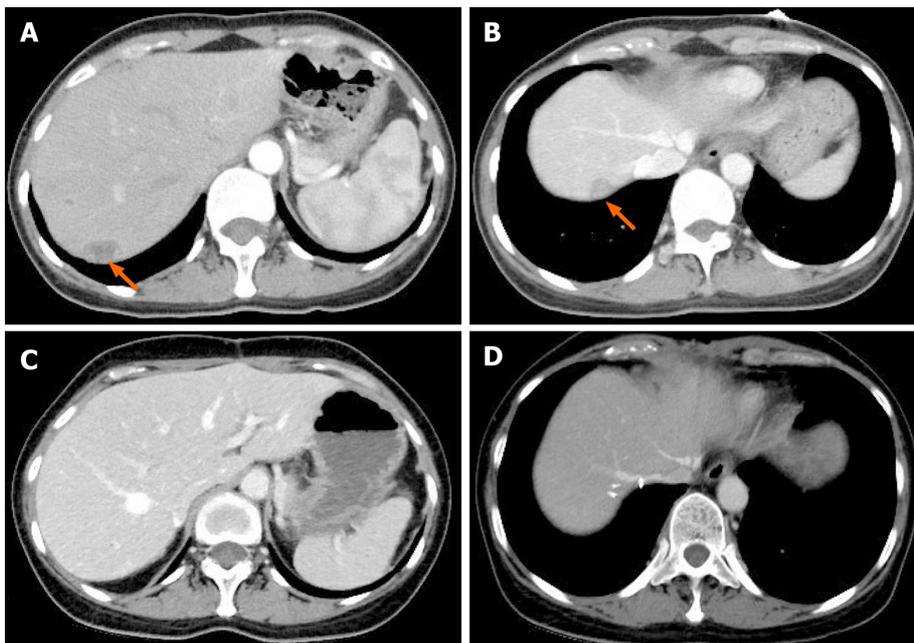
Computed tomography images of the patient with hepatic recurrence. A and B: Abdominal computed tomography (CT) scan detected low-density nodules under the liver capsule. The arrows indicate metastatic nodules in the liver, and the diameters of the metastatic lesions ranged from 1.5-2.5 cm; C and D: CT appearances of the liver after second resection of tumors in the liver plus partial hepatectomy.
